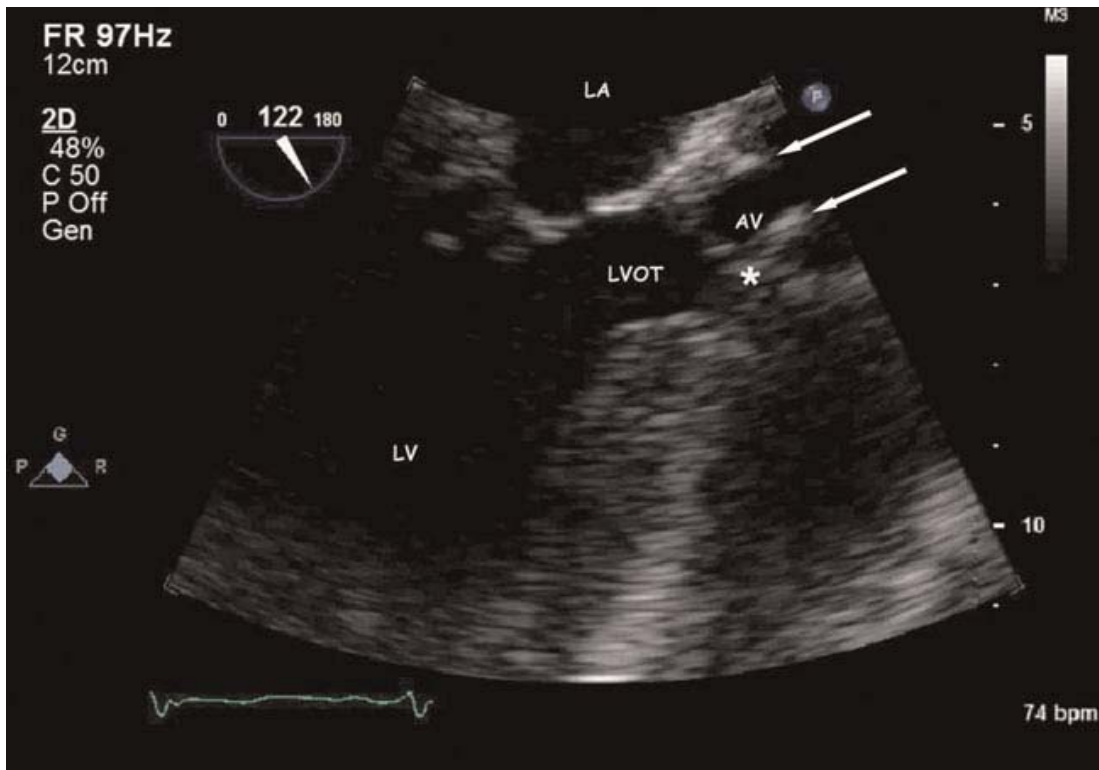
Transoesophageal echocardiography. Mild restrictive movement of aortic valve leaflets (arrows). The membranous ridge (*) is located in the LVOT proximal to the aortic valve (AV). LV, left ventricle; LA, left atrium.
